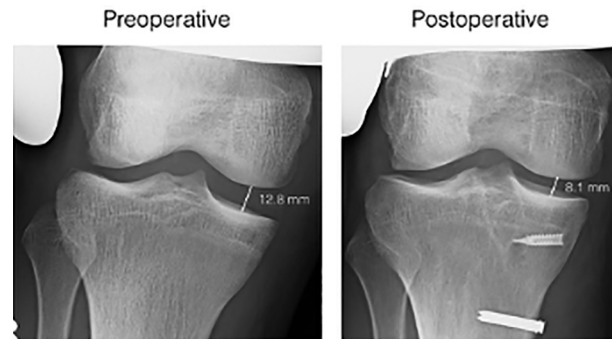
Valgus stress radiographs showing a medial gap opening of 12.8 mm preoperative and 8.1 mm postoperative.
